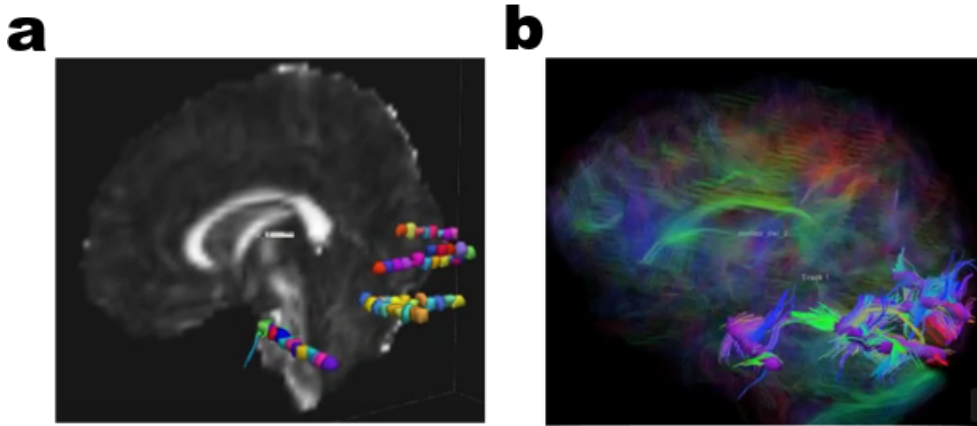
ROI generation procedure a: A ROI of 3mm radius is created for each contact. ROIs were after superposed over a structural image. Notice several intracranial electrodes located in the occipital area. ROIs are not isometric, due to transformation deformations when going to DWI space from T1. b: Same subject, with the tractography reconstructed and highlighted the streamlines crossing specific ROIs. These streamlines were accounted for structural connectivity.
